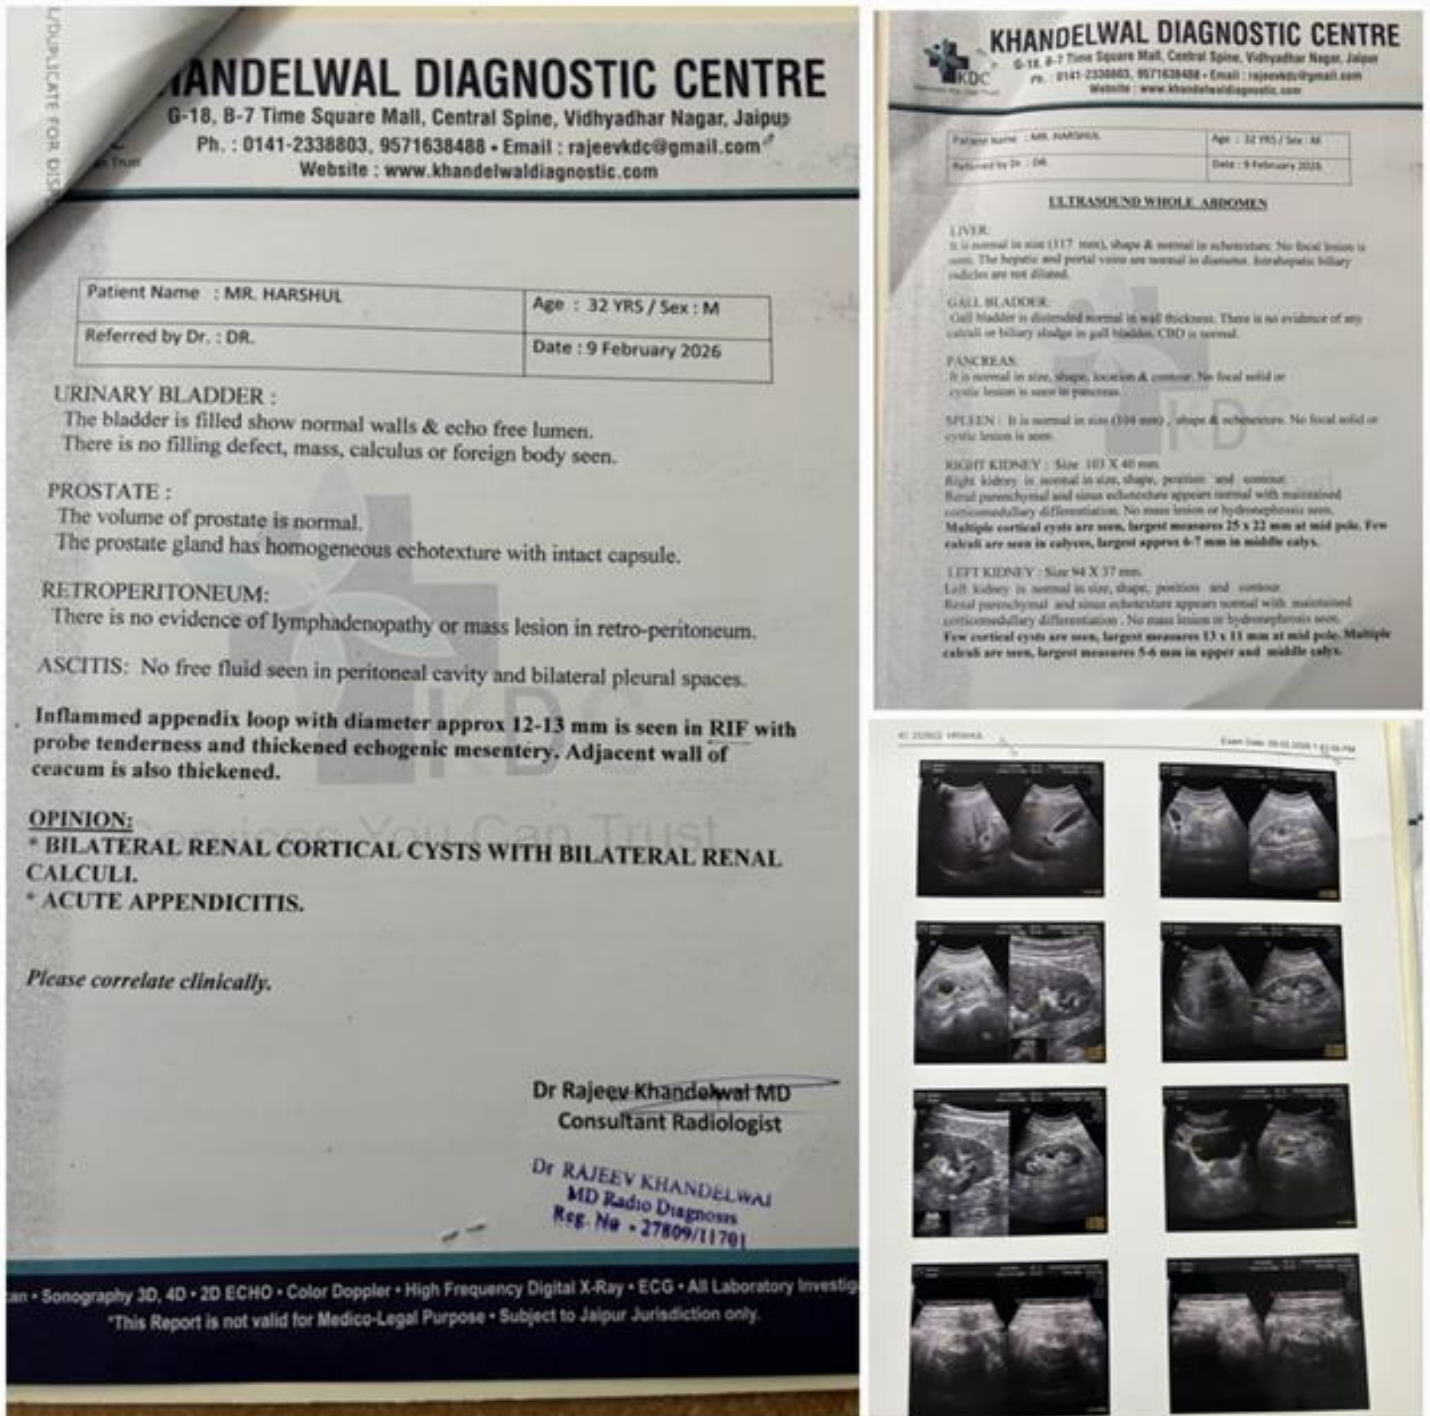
Baseline abdominal ultrasonography (9 February 2026) showing an inflamed appendix loop with diameter approx. 12-13 mm in RIF with probe tenderness, thickened echogenic mesentery, and caecal wall thickening, suggestive of acute appendicitis.
